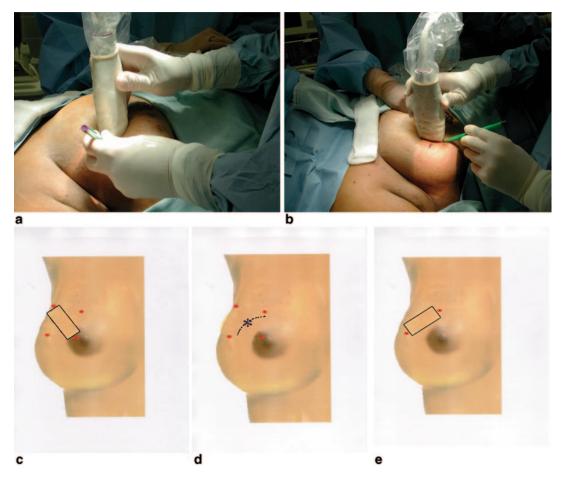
Wire insertion may be avoided by simply performing ultrasound imaging using orthogonal views directly over the lesion. (Courtesy of Howard Snider, MD)
